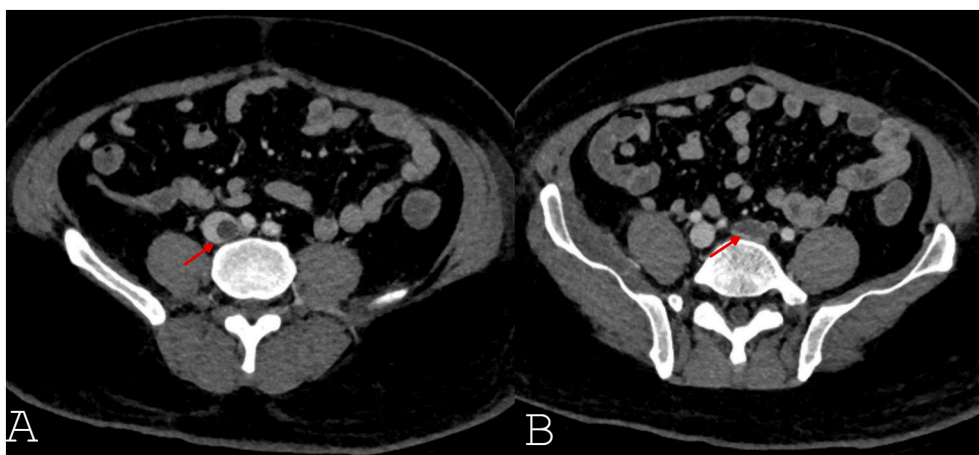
Axial CT venogram of the lower extremity following bilateral iliofemoral arterial thrombectomies. A) Filling defect in the infrarenal inferior vena cava representing nonocclusive thrombus. B) Occlusive thrombus in the left common iliac vein.
